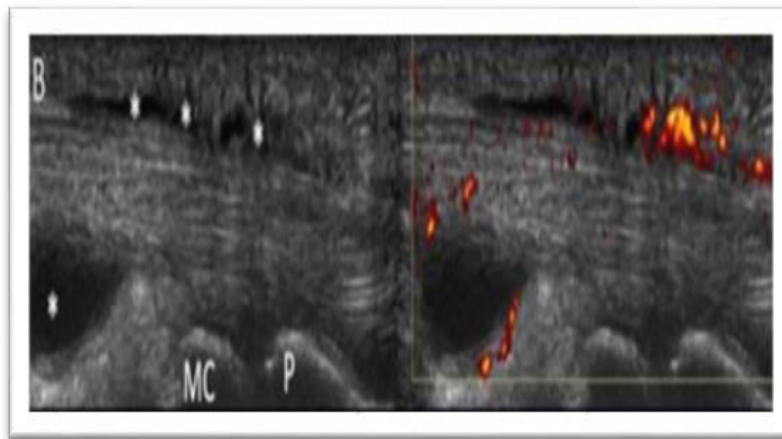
Characteristic ultrasound findings of early psoriatic arthritis ; longitudinal view through the flexor tendon of the digit shows thickening of the fluid and synovium fluid inside the tendon sheath. A strong Doppler signal is also observed within the tendon sheath.
